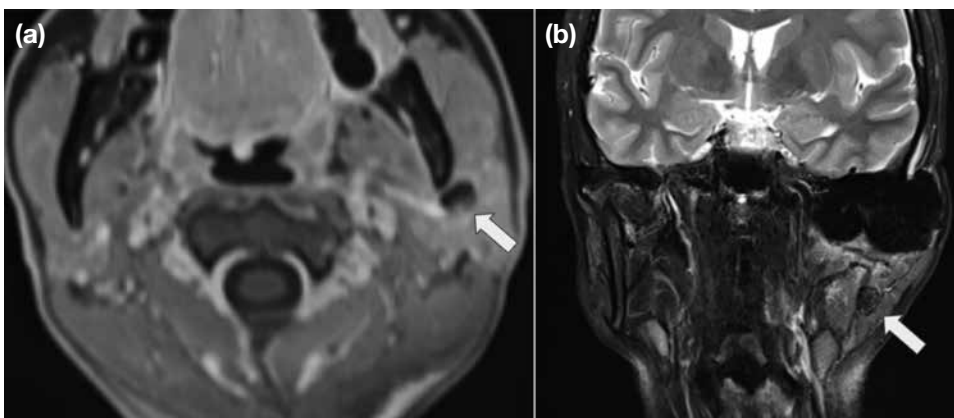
(a) Axial T1-weighted and (b) coronal T2-weighted images show a non-enlarged lymph node (arrows) along the jugular chain with similar T1- and T2-weighted hypointense signal to the primary tumour.
